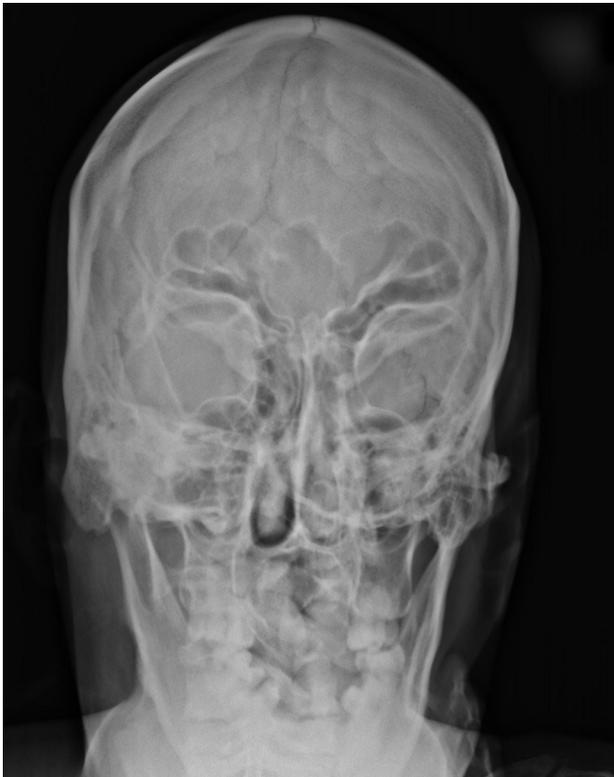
Skull X-ray showed diffuse thickened cranial vault, enlarged frontal sinus, and protruded mandible.
